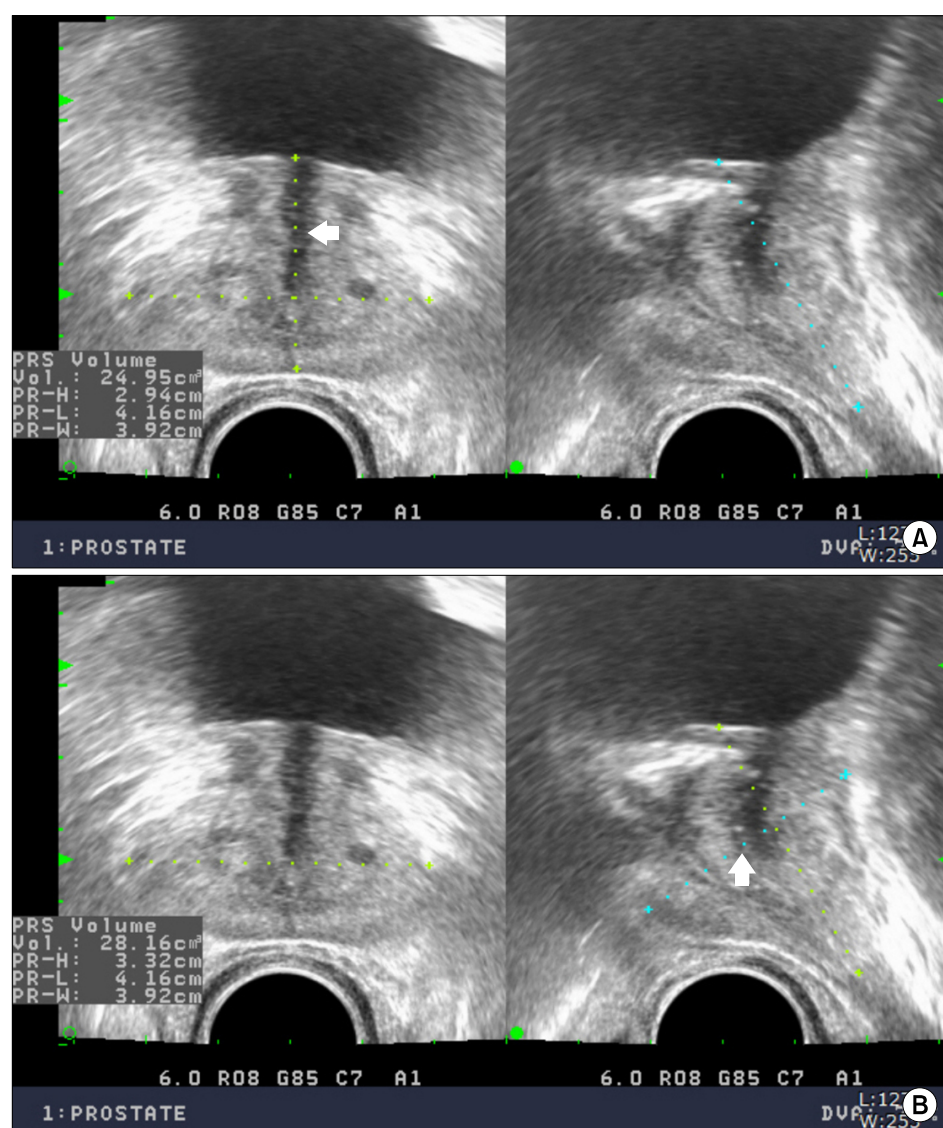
Measurement of prostate volume by transrectal ultrasonography. (A) Height (arrow) was measured by transaxial scanning (2.94 cm), and prostate volume was calculated as 24.95 mL. (B) Height (arrow) was measured by midsagittal scanning (3.32 cm), and prostate volume was calculated as 28.16 mL.
